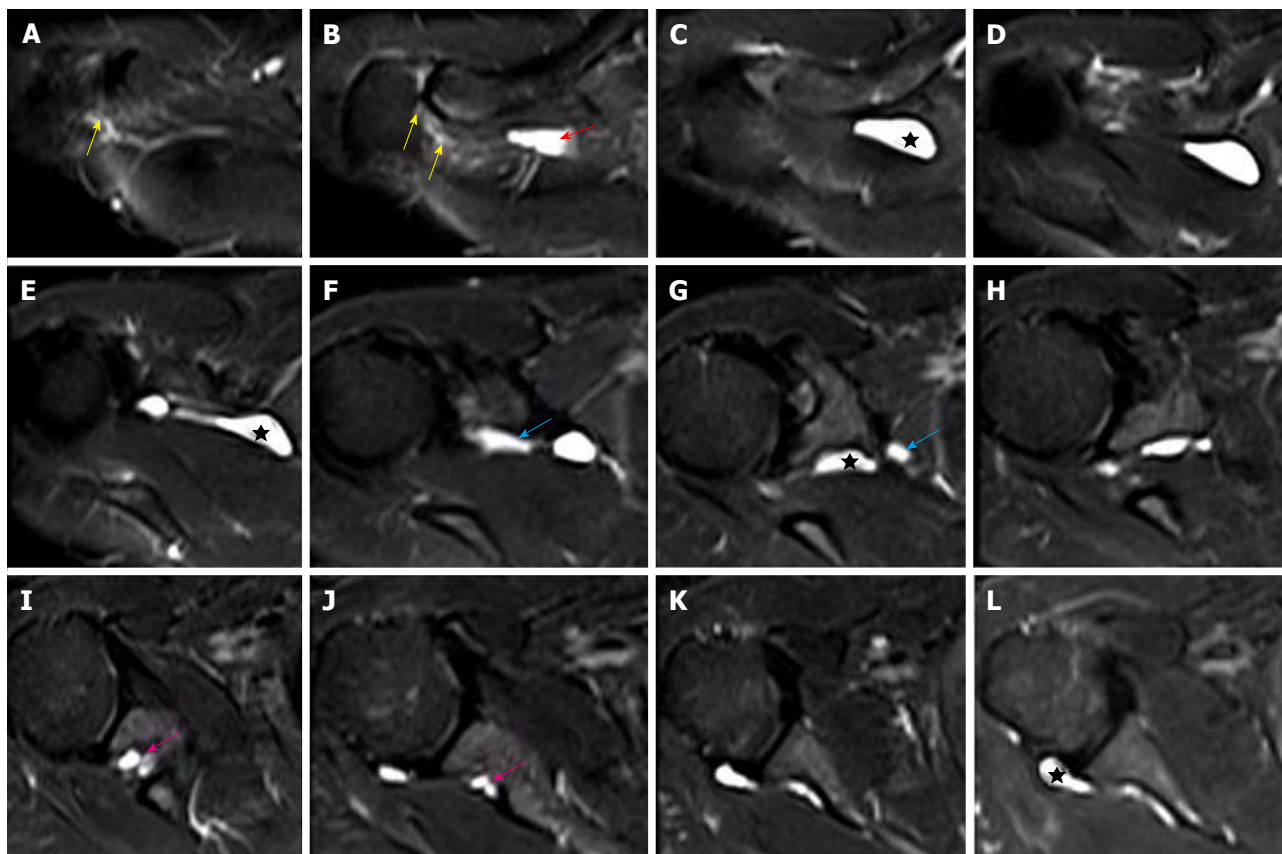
Images A-L show serial T2-weighted fat suppressed axial sections of the right shoulder, outlines the longitudinally oriented cyst (stars) along the course of the suprascapular nerve. The cyst extends from the level of the acromioclavicular joint (B) to the posterior aspect of glenohumeral joint (L). A narrow joint connection extends along the expected course of the articular branch of the suprascapular nerve to the acromioclavicular joint (yellow arrows). Further descent of the intraneural cyst through the posterior triangle into the suprascapular and spinoglenoid notches are demonstrated by red, blue and pink arrows respectively. No obvious labral or capsular tear or degeneration of joint is noted on magnetic resonance imaging.
